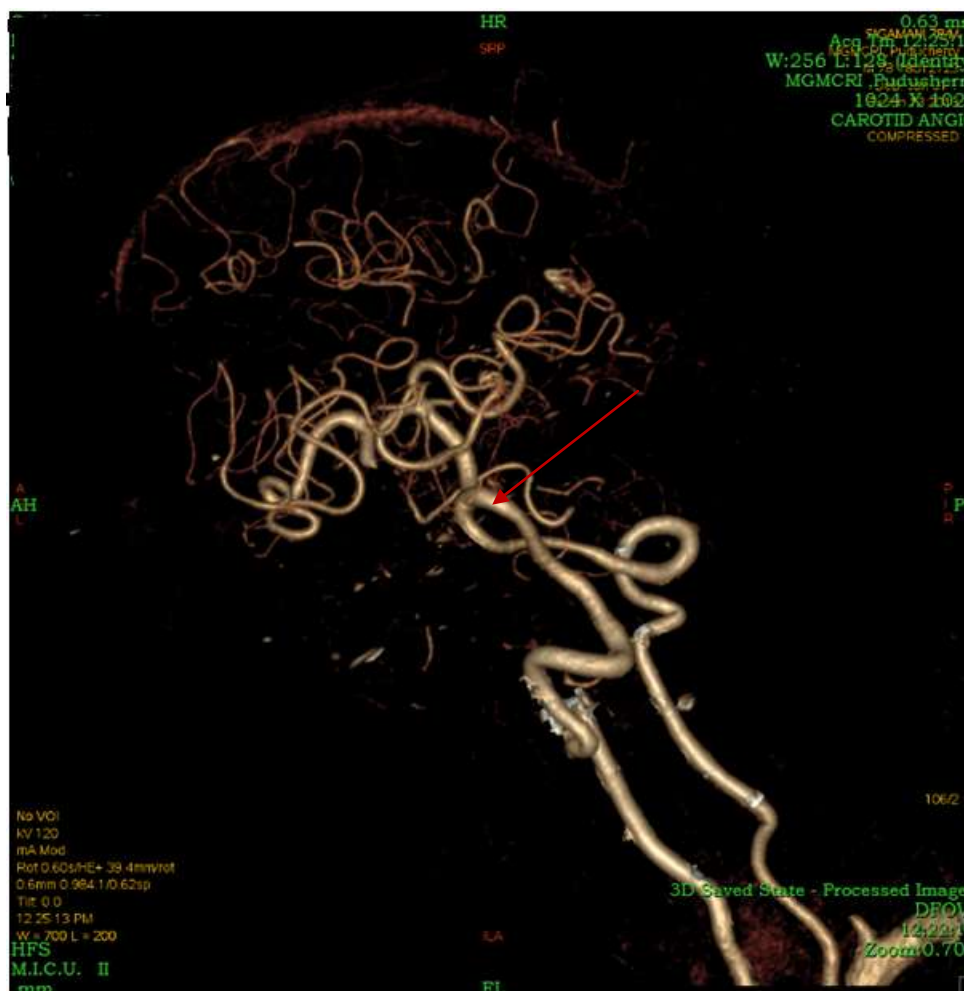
CT Carotid Angiogram. Arrow shows dolichoectasia
